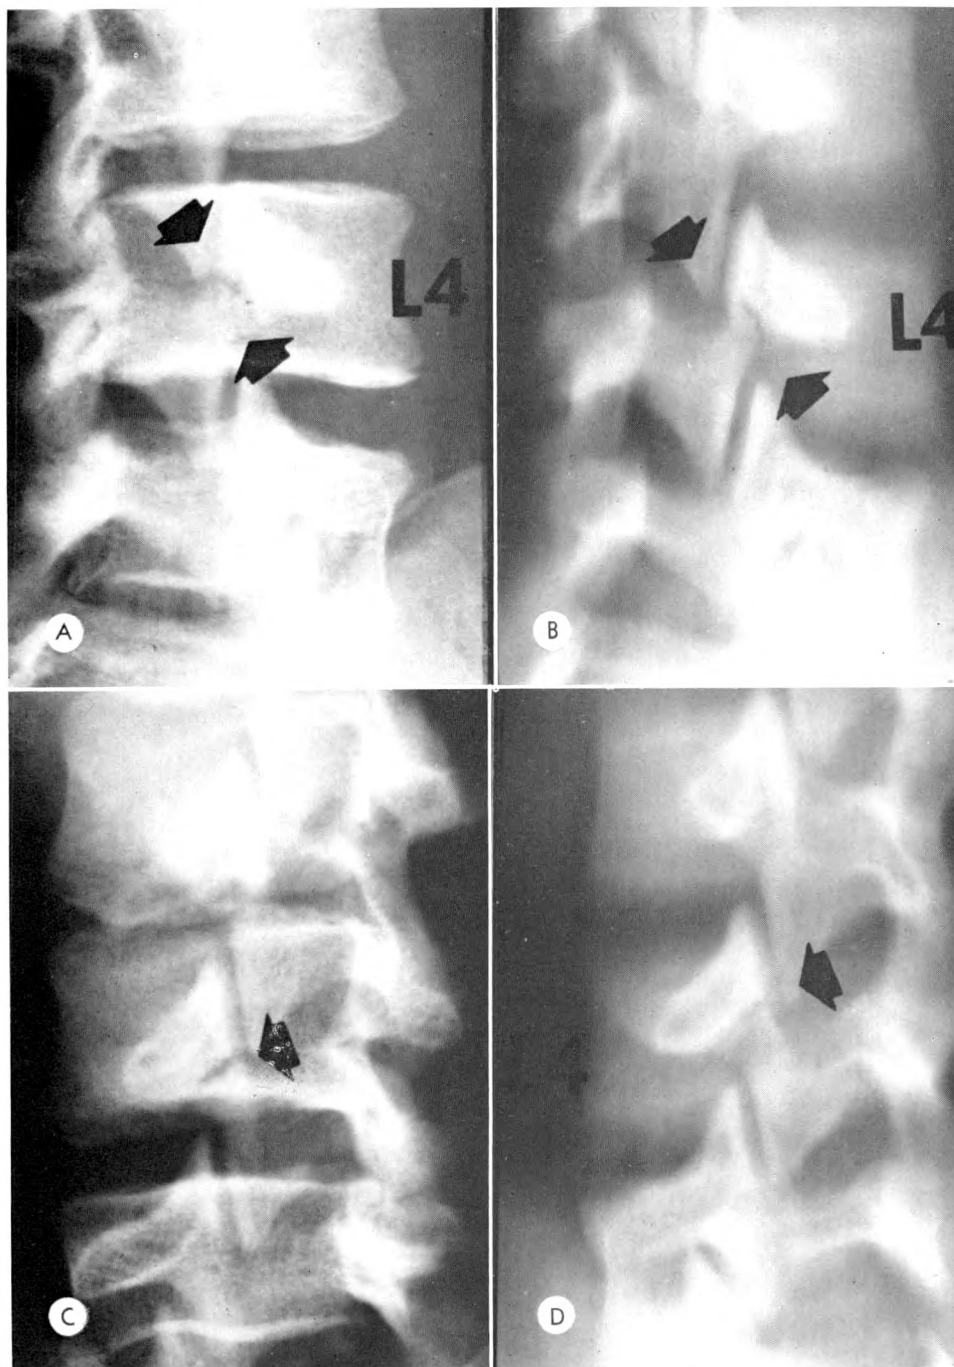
(A-D) Plain roentgenograms and oblique laminagrams obtained in 1958 show fracture lines in both isthmi of L4 vertebra.
